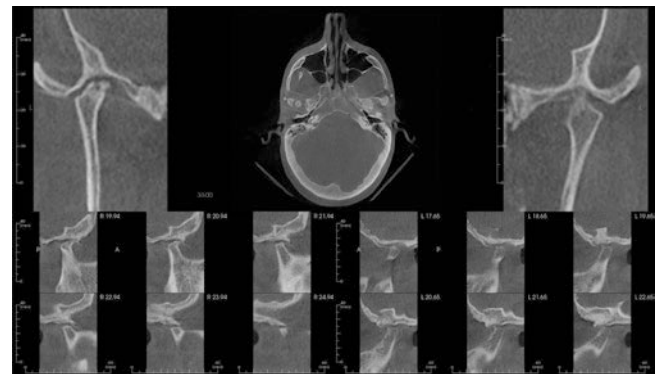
CBCT of the same patient from Fig. 50.2, showing severe degenerative joint disease with coronal and sagittal image reconstruction
